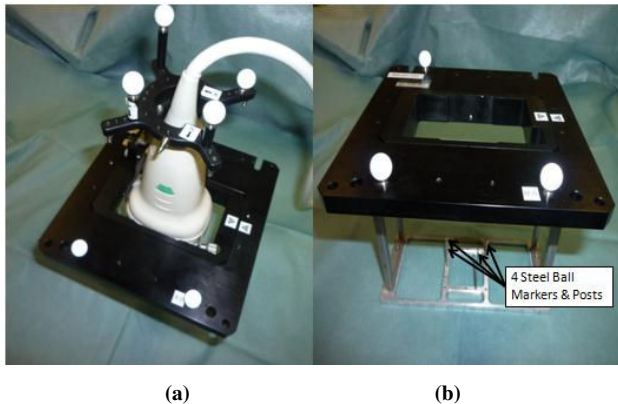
Registration tool for ultrasound image and 3D ultrasound probe.
